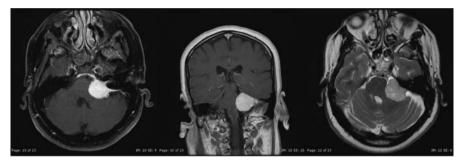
Cerebellopontine angle meningioma in an 61-year-old woman. An axial T2 and gadolinium-enhanced coronal and axial T1 MRI scan, showing a meningioma based around the internal acoustic meatus. Note extension into the meatus but no expansion. Also note significant dural tail both anteriorly along the clivus and posteriorly along the petrous ridge and also attachment to the tent. This patient presented with facial numbness, ataxia and episodes of nausea
